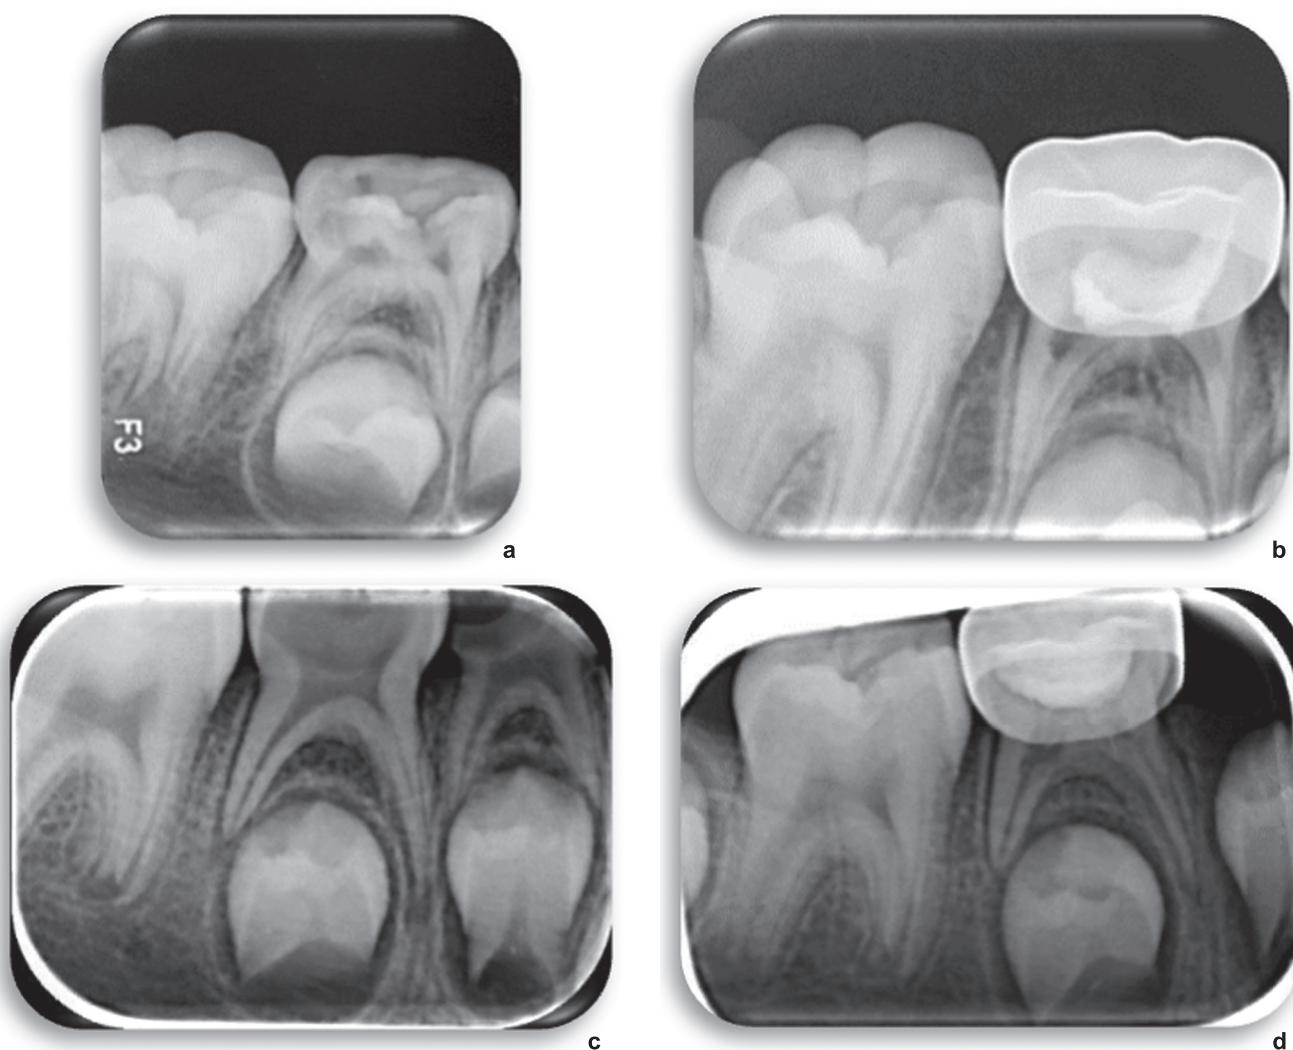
a and c – Preoperative periapical radiographs showing carious teeth. b – Internal resorption seen in the 12th month of control of the diode laser-treated tooth. d – Internal resorption seen in the 12th month of control of the LLLT+KH-treated tooth.
